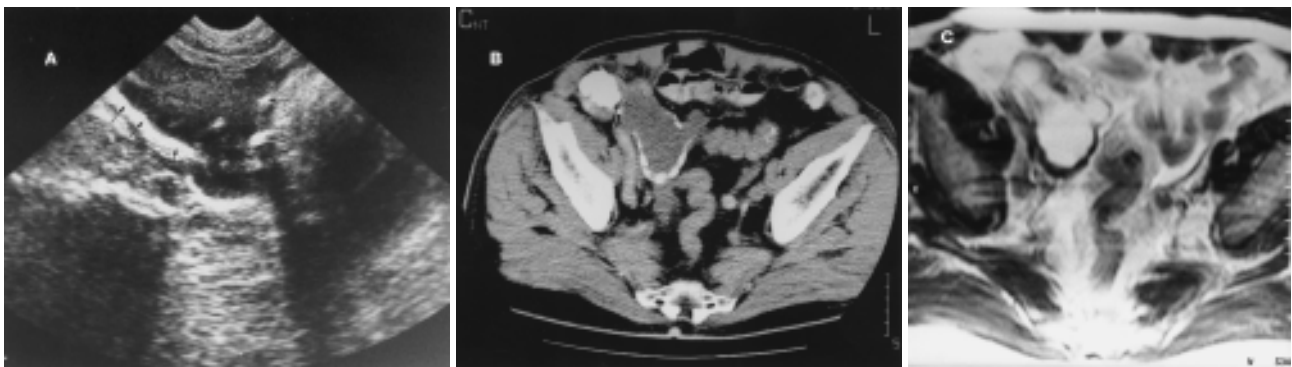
A. Ultrasonogram of the pelvis which reveals a hypoechoic mucocele of the appendix with low intensity echoes and linear or nodular calcifications of the wall (arrows). B. Axial CT scan of the pelvis which clearly reveals the appendiceal mucocele, with linear and nodular calcifications of the wall and in close proximity to the cecum (white arrow). C. Axial MR T2-weighted image which shows the mucocele with high signal intensity and the calcification of the wall.
